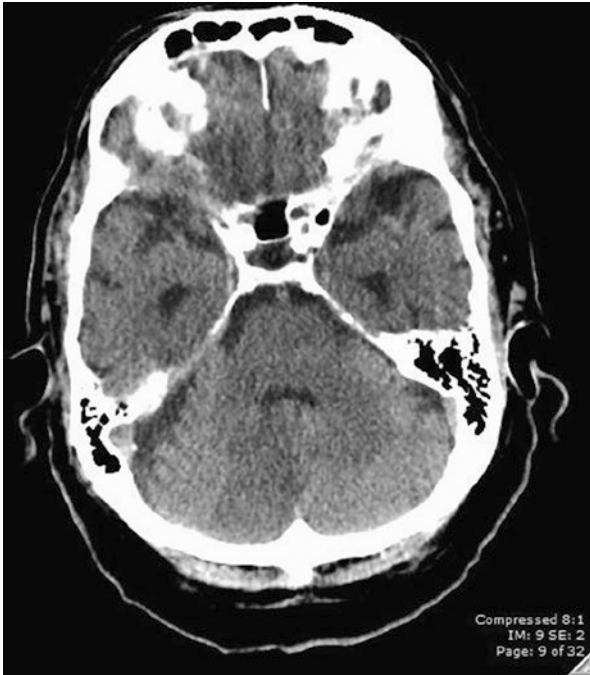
Non-contrast head CT demonstrating a right cerebellar hypodensity
